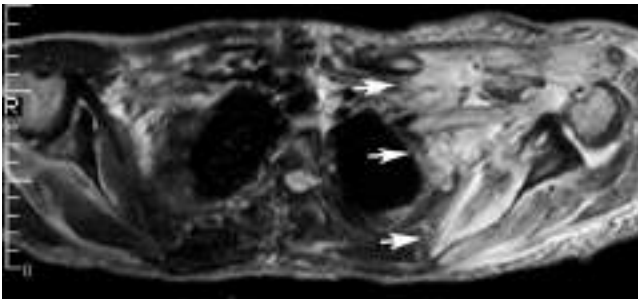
Radiation therapy. Axial T2-weighted MR image of the upper chest in a patient previously treated with radiation therapy to the left shoulder and axilla region shows diffuse edema in the radiated soft tissues. Note sharp, straight margin between the radiated and normal tissues (arrows). (Reprinted with permission from May DA, Disler DG, Jones EA, et al. Abnormal signal within skeletal muscle in magnetic resonance imaging: patterns, pearls, and pitfalls. *Radiographics*. 2000; 20:S295-S315.)
